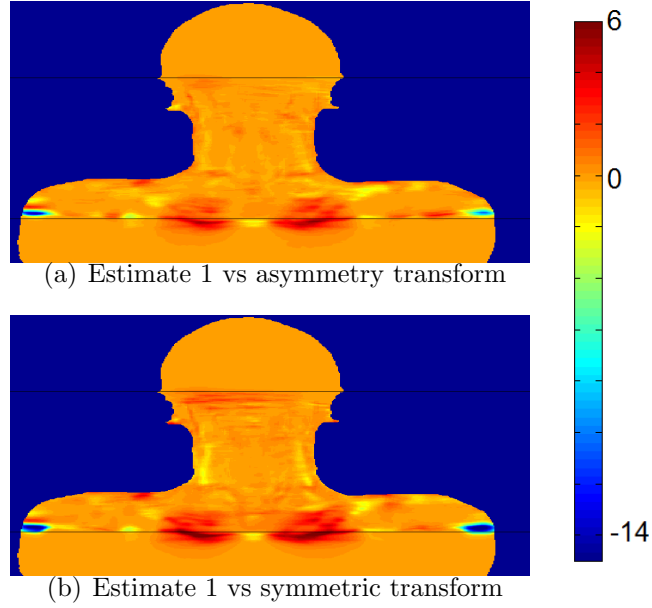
Coronal planes dose difference images between different transforms to compute the cumulative dose: (a) estimate 1 vs asymmetry, (b) estimate 1 vs symmetric. Black horizontal lines represent the CBCT field of view and color scale is in Gy unit.
